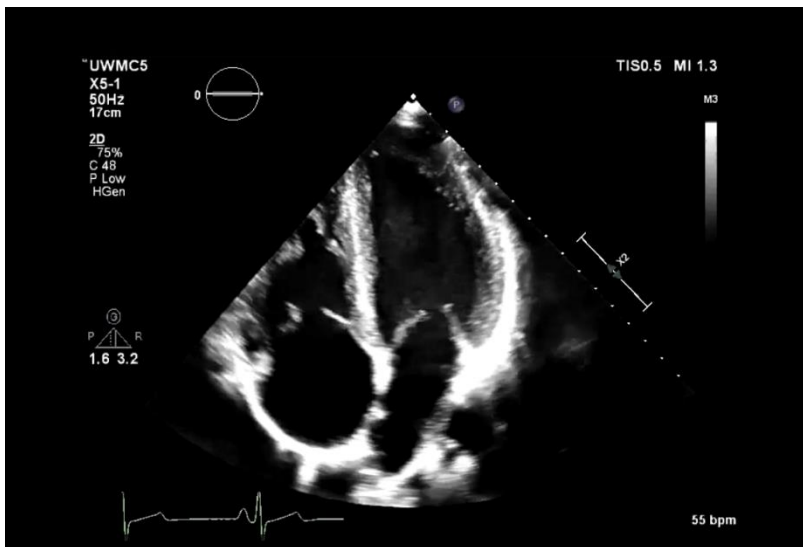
Typical apical four-chamber view
